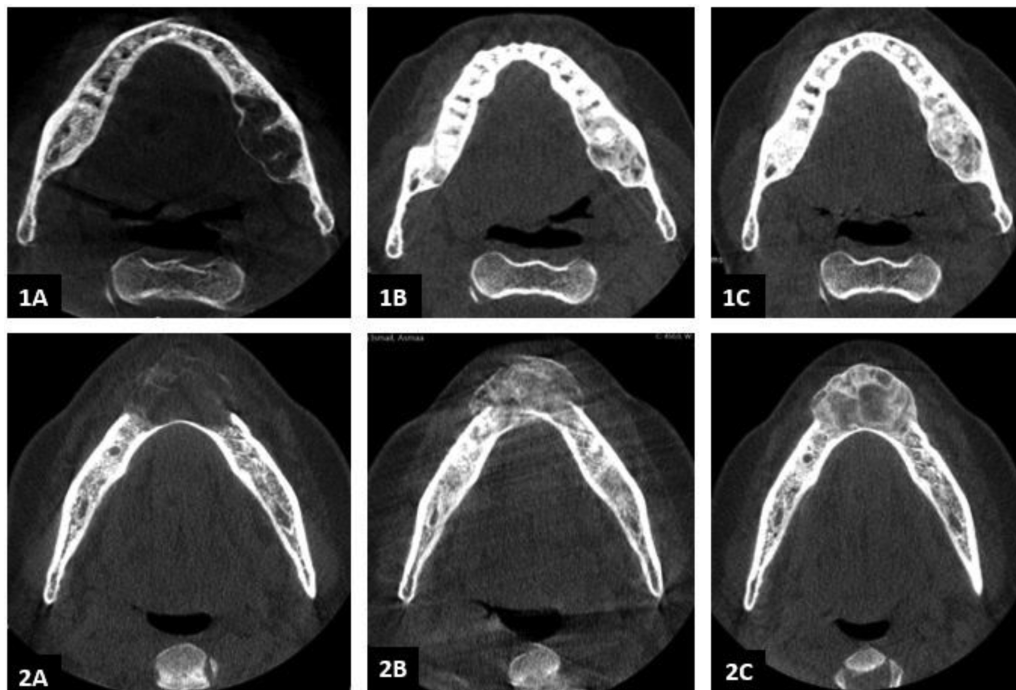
CT images of patient 1. (1A) patient 1 baseline CT; central giant cell granuloma (CGCG) body of the left mandible, (1B) patient 1 after 3 cycles; cortical thickening and central ossification, (1C) patient 1 after 10 cycles; increased ossification 80%. (2A) patient 2 baseline CT; CGCG of the anterior mandible, (2B) patient 2 after 3 cycles; cortical thickening and central ossification of the affected mandible, (2C) patient 2 after 6 cycles; further increase of ossification.
